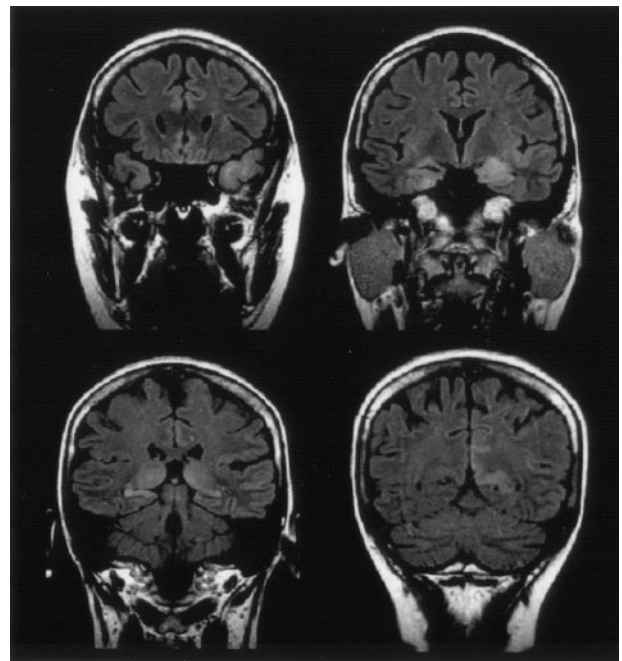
Anaplastic (limbic) astrocytoma of WHO grade III. Coronal 3-mm-thick FLAIR fast spin-echo sections show increased volume and signal intensity of both temporopolar cortices, the amygdala, hippocampi, thalami, and left parietal cortex. Because repeated CSF investigation showed a slightly increased protein content (54–95 mg/dL) and 6–8 cells per microliter, limbic encephalitis was suspected.
